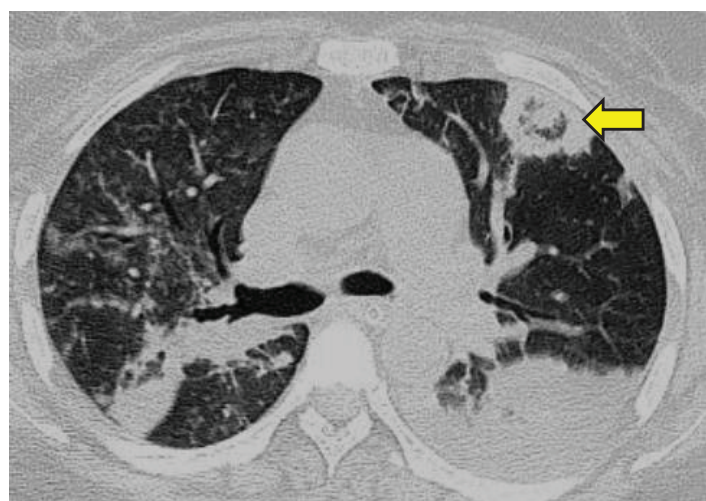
CT Chest showing Nodule with RHS
